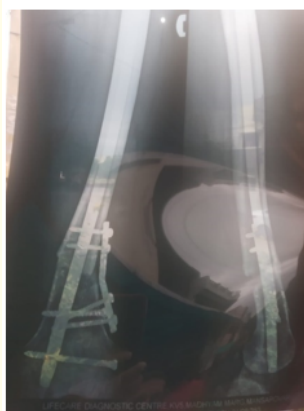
Xray showing post operative femur interlocking nail with augmentation with plate.
